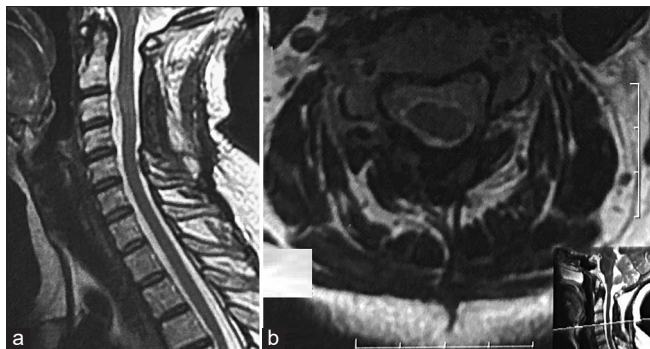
Sagittal (a) and axial (b) sections of a cervical spine magnetic resonance imaging on T2-weighted imaging (WI) (a) and T1-WI (b) showing a complete removal of the cavernoma.
